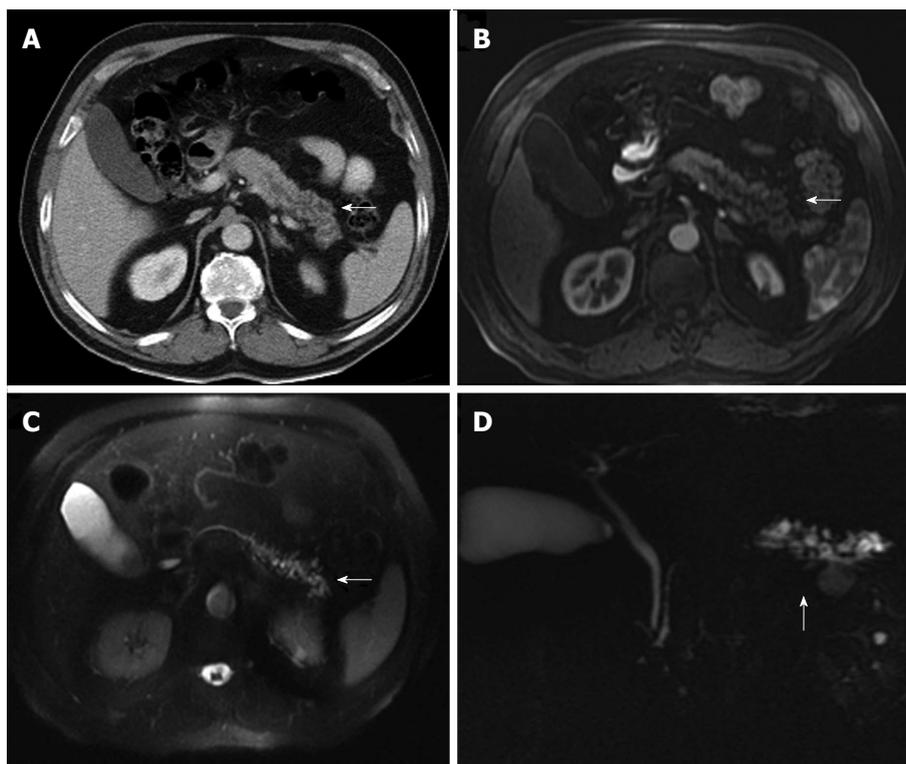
Multidetector computed tomography image. A: Cystic dilatation of the main pancreatic duct and some of its branches in the pancreatic tail. Ductal communication with the tumor cannot be clearly identified; B-D: In contrast-enhanced axial T1 (B) and T2-weighted (C) magnetic resonance images and in magnetic resonance imaging cholangiography (D) ductal communication can be easily detectable.
